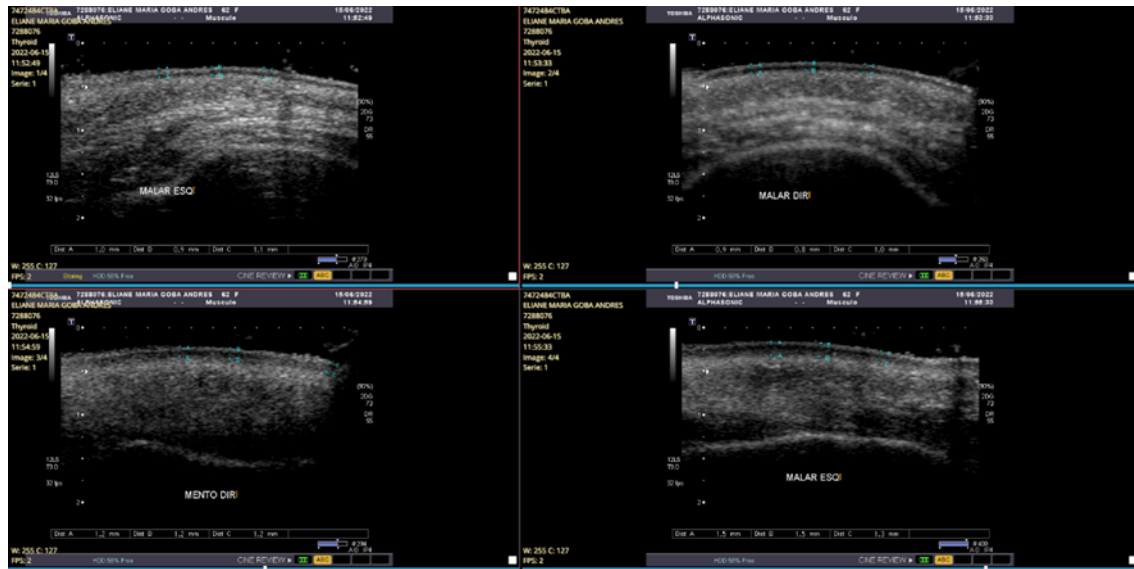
Right and left malar and mentonian evaluation by ultrasound imaging after oral and topical silicon in OR group.
